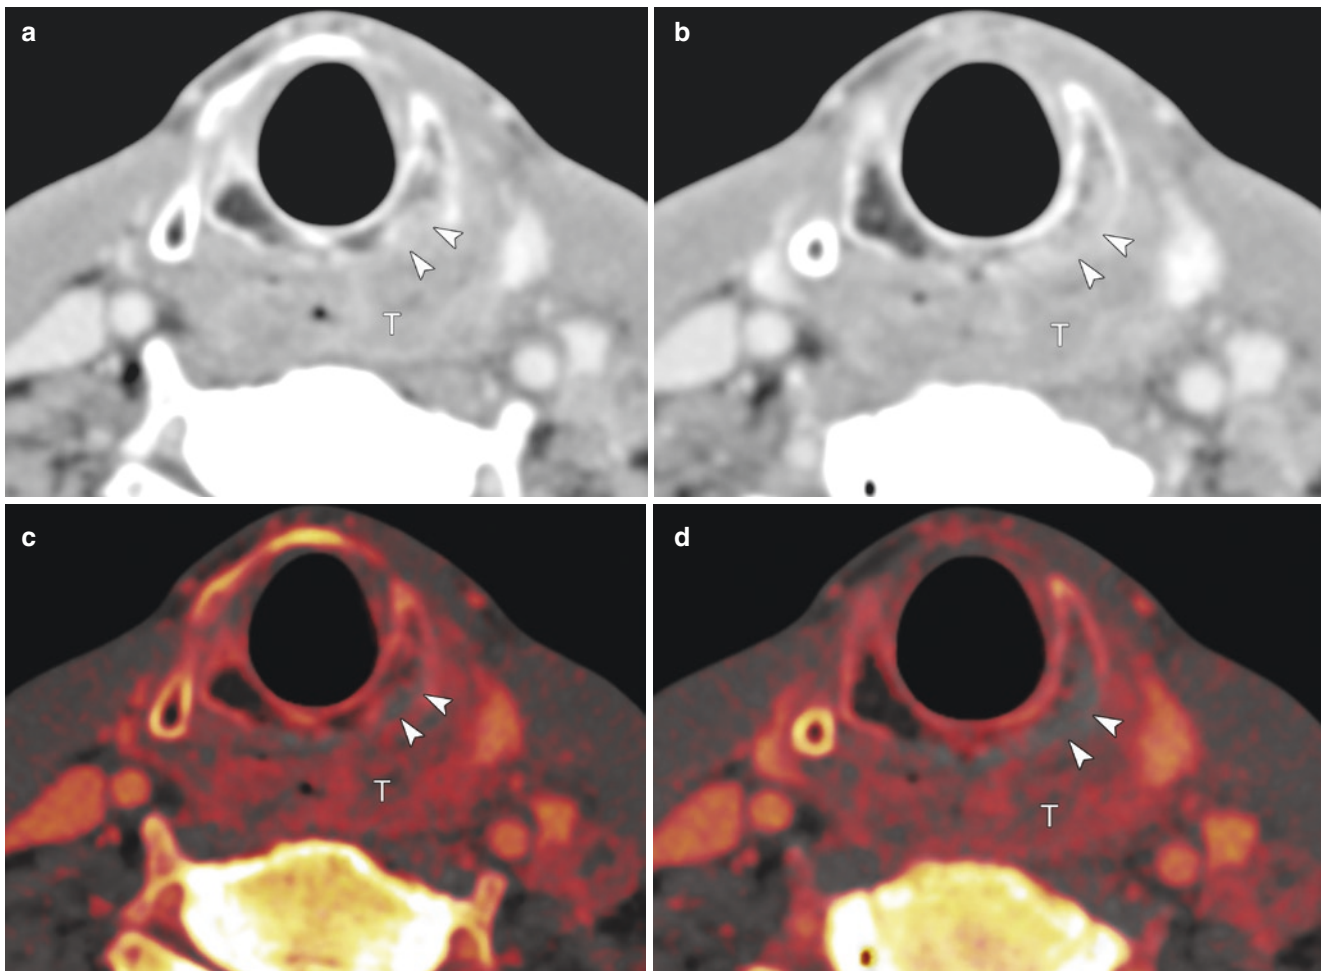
Negative findings for invasion in the cricoid cartilage by dual-energy CT with hypopharyngeal carcinoma. WA image (a) shows a large tumor mass (T) in postcricoid area. Left lamina of the cricoid cartilage shows lysis change and has been substituted by the tumor
